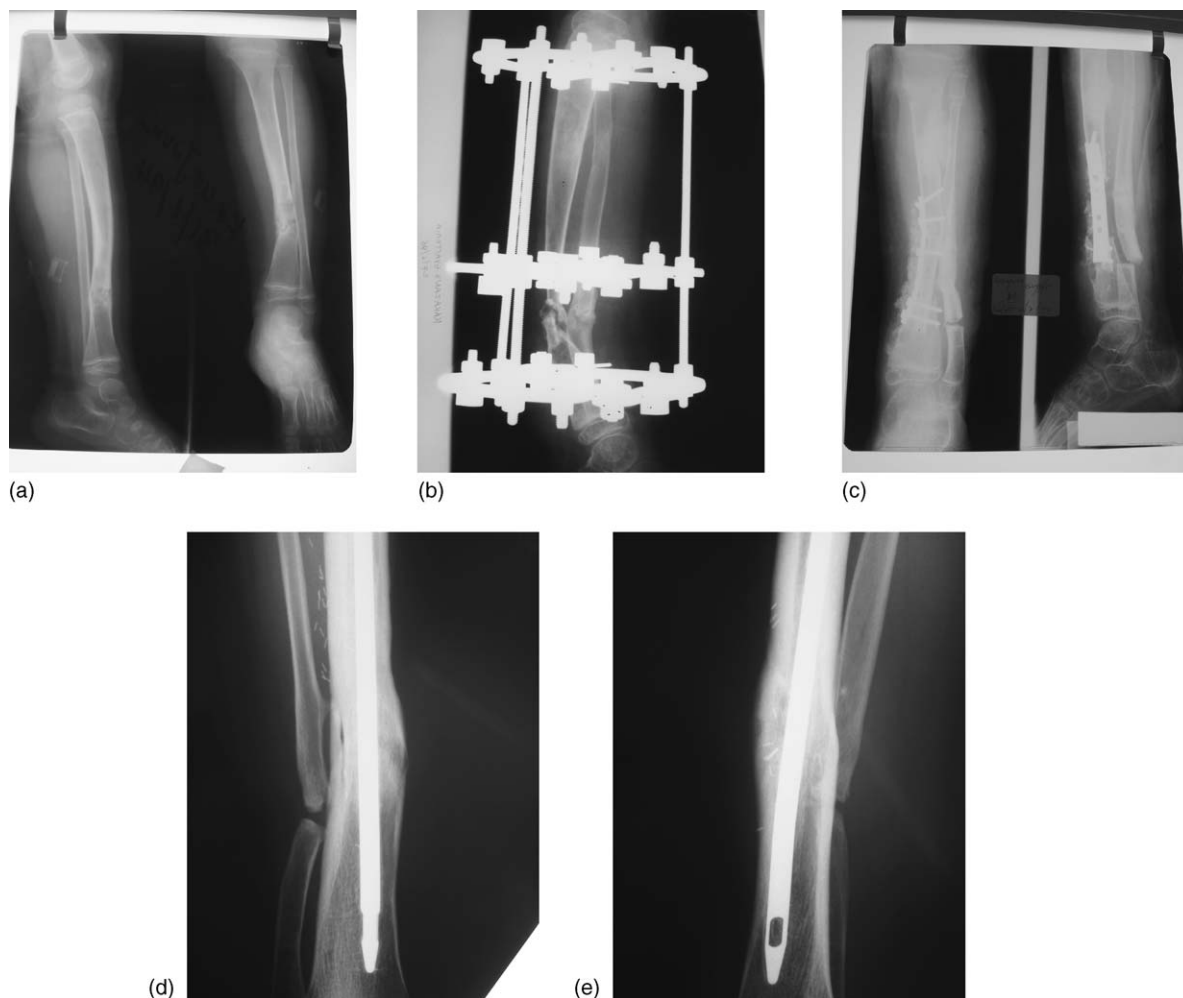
(a) Congenital pseudoarthrosis of the distal third of the tibia in a 3-year-old girl. (b) Various surgical procedures, all of which failed, were attempted to treat the congenital pseudoarthrosis of the tibia. Shown here is an external Ilizarov fixator that was attempted at age 5 years and which also failed. (c) After the previous failures, a vascularised fibular graft was used to treat the pseudoarthrosis (age 7 years). (d) Anteroposterior and (e) lateral radiographs showing complete healing and remodelling of the tibia with full incorporation of the fibular graft 7 years postoperatively. The IM nailing was used to treat a recent proximal fracture of the tibia.
